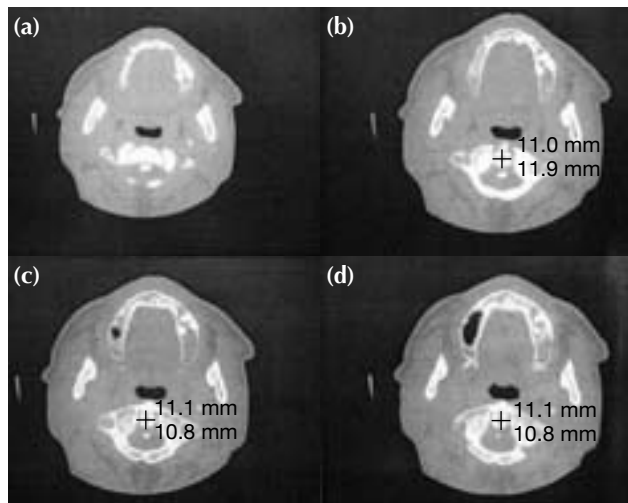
Axial computed tomographic scan sections at (a) the true base of odontoid process where the outer diameter is not well-delineated. Measurements are taken at (b) the base where the outer diameter is well-delineated, and at (c) 1.2 mm and (d) 2.4 mm above the base.
